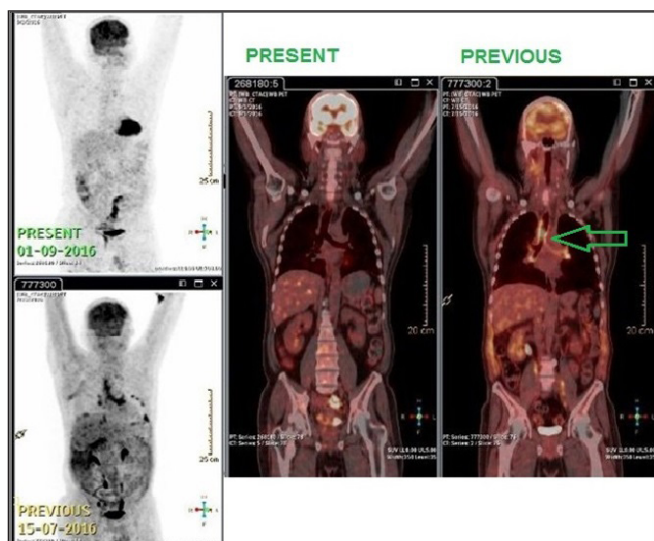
Comparative images of previous (baseline) and present (at 6 weeks follow up) ¹⁸F-FDG-PET/CT scans. The baseline scans show enhanced metabolic activity in the nodular circumferential wall thickening with calcification in the trachea, extending distally up to the main bronchi and proximal lobar bronchi (green arrow)
